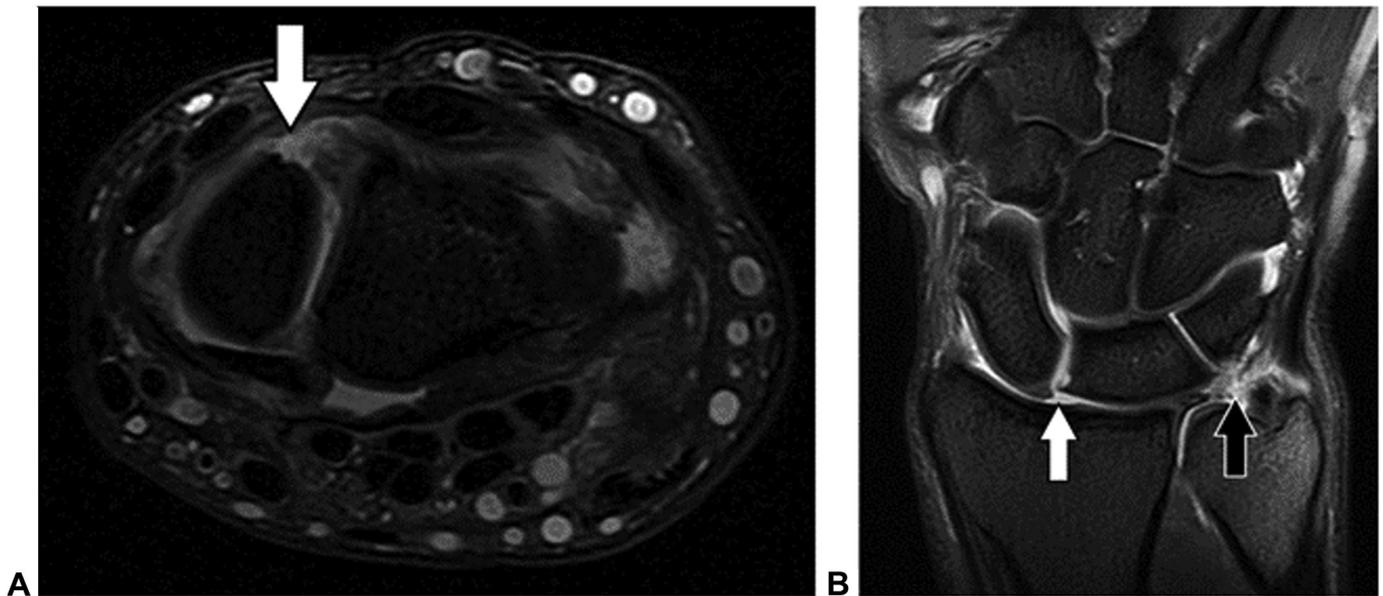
Stage 2 SLIL injury in a 26-year-old professional basketball player with a recent fall on an outstretched hand. The scapholunate interval and angle were within normal limits on static posteroanterior, dynamic clenched fist, and lateral radiographs. A Axial PDW fat-suppressed MR image shows a torn SLIL dorsal band (arrow) from the scaphoid. B Coronal PDW fat-suppressed MR image shows a torn SLIL interosseus band (white arrow) and an incidental tear of the central triangular fibrocartilage (black arrow). Reparability of the SLIL dorsal band can be suggested with imaging if the tear appears noncomplex and nonelongated but is ultimately determined at surgery. (Adapted with permission from Palisch et al¹⁰¹).
